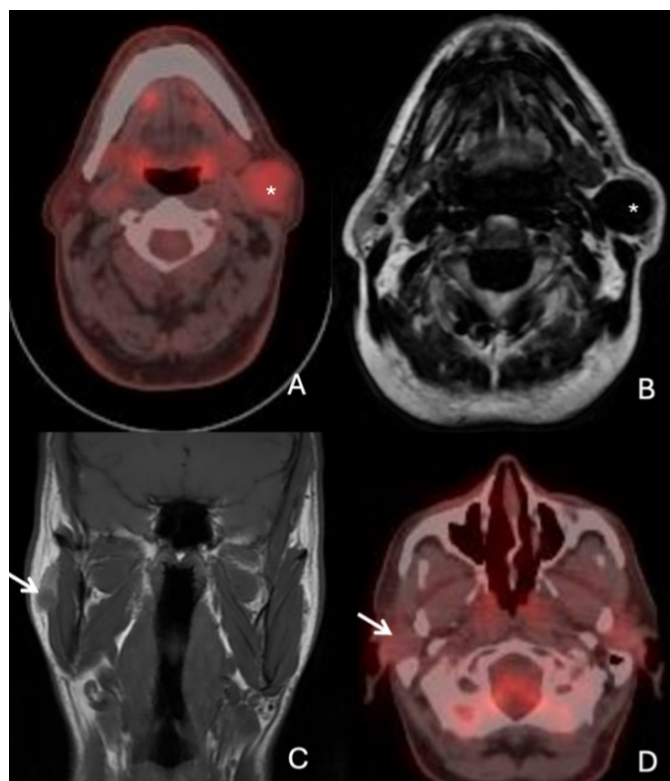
A 60-year-old female diagnosed with adenocystic carcinoma of the left parotid gland. Imaging revealed a solid lesion measuring 27x25x40 mm in the posterior inferior part of the gland (A), characterized by hypointense lesion on axial LAVA Flex MR image (B). A 45-year-old male initially diagnosed with a pleomorphic adenoma of the right parotid gland based on imaging findings showing dimensions of 12.5 x 13.5 x 13 mm with mild hypointense lesion on coronal Fast Spin Echo T1-weighted images (C). PET/CT imaging, however, revealed no malignant activity within the lesion (D).
